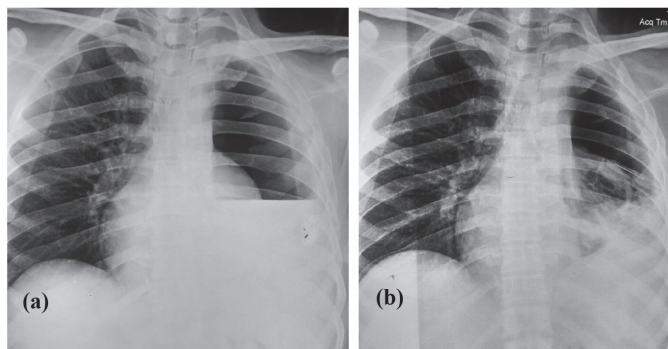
(a) Pre and (b) post tube thoracostomy chest radiograph.
